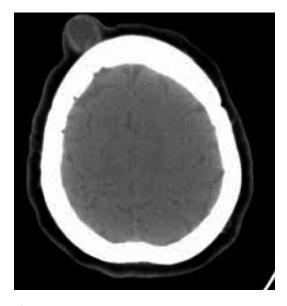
CT scan of the skull showing no intracranial extension of the dermoid cyst in the scalp
